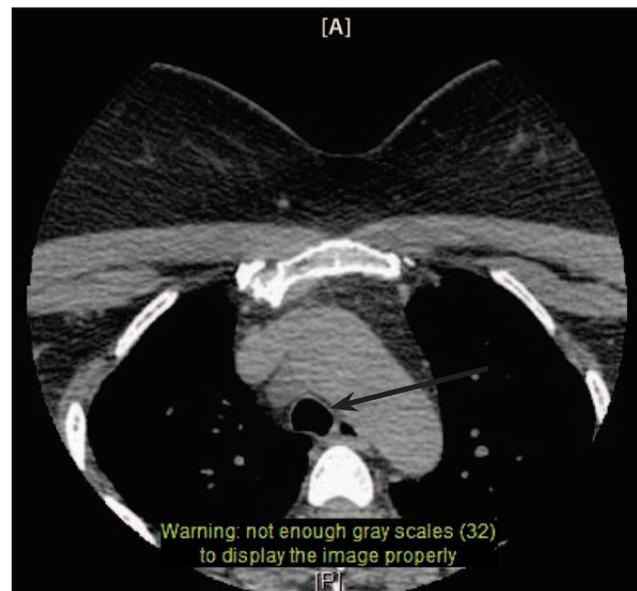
Non contrast computed tomography (CT) neck and thorax showing slight compression of the left lateral aspect of the trachea with marginal displacement to the right. The transverse diameter of the trachea is 11 mm with a measurement of 15 mm at the level of the lower pole of the left thyroid lobe and a similar diameter below the vocal cords in the upper portion of the thyroid.
